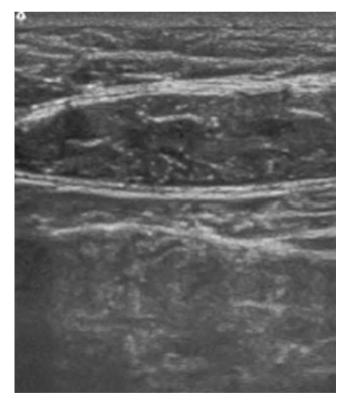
2D ultrasound of abdominal wall near the lateral border of the rectus. Tissue layers from top to bottom are subcutaneous fat, anterior rectus sheath, rectus muscle, posterior rectus sheath, pre-peritoneal fat, parietal peritoneum and mesenteric fat
